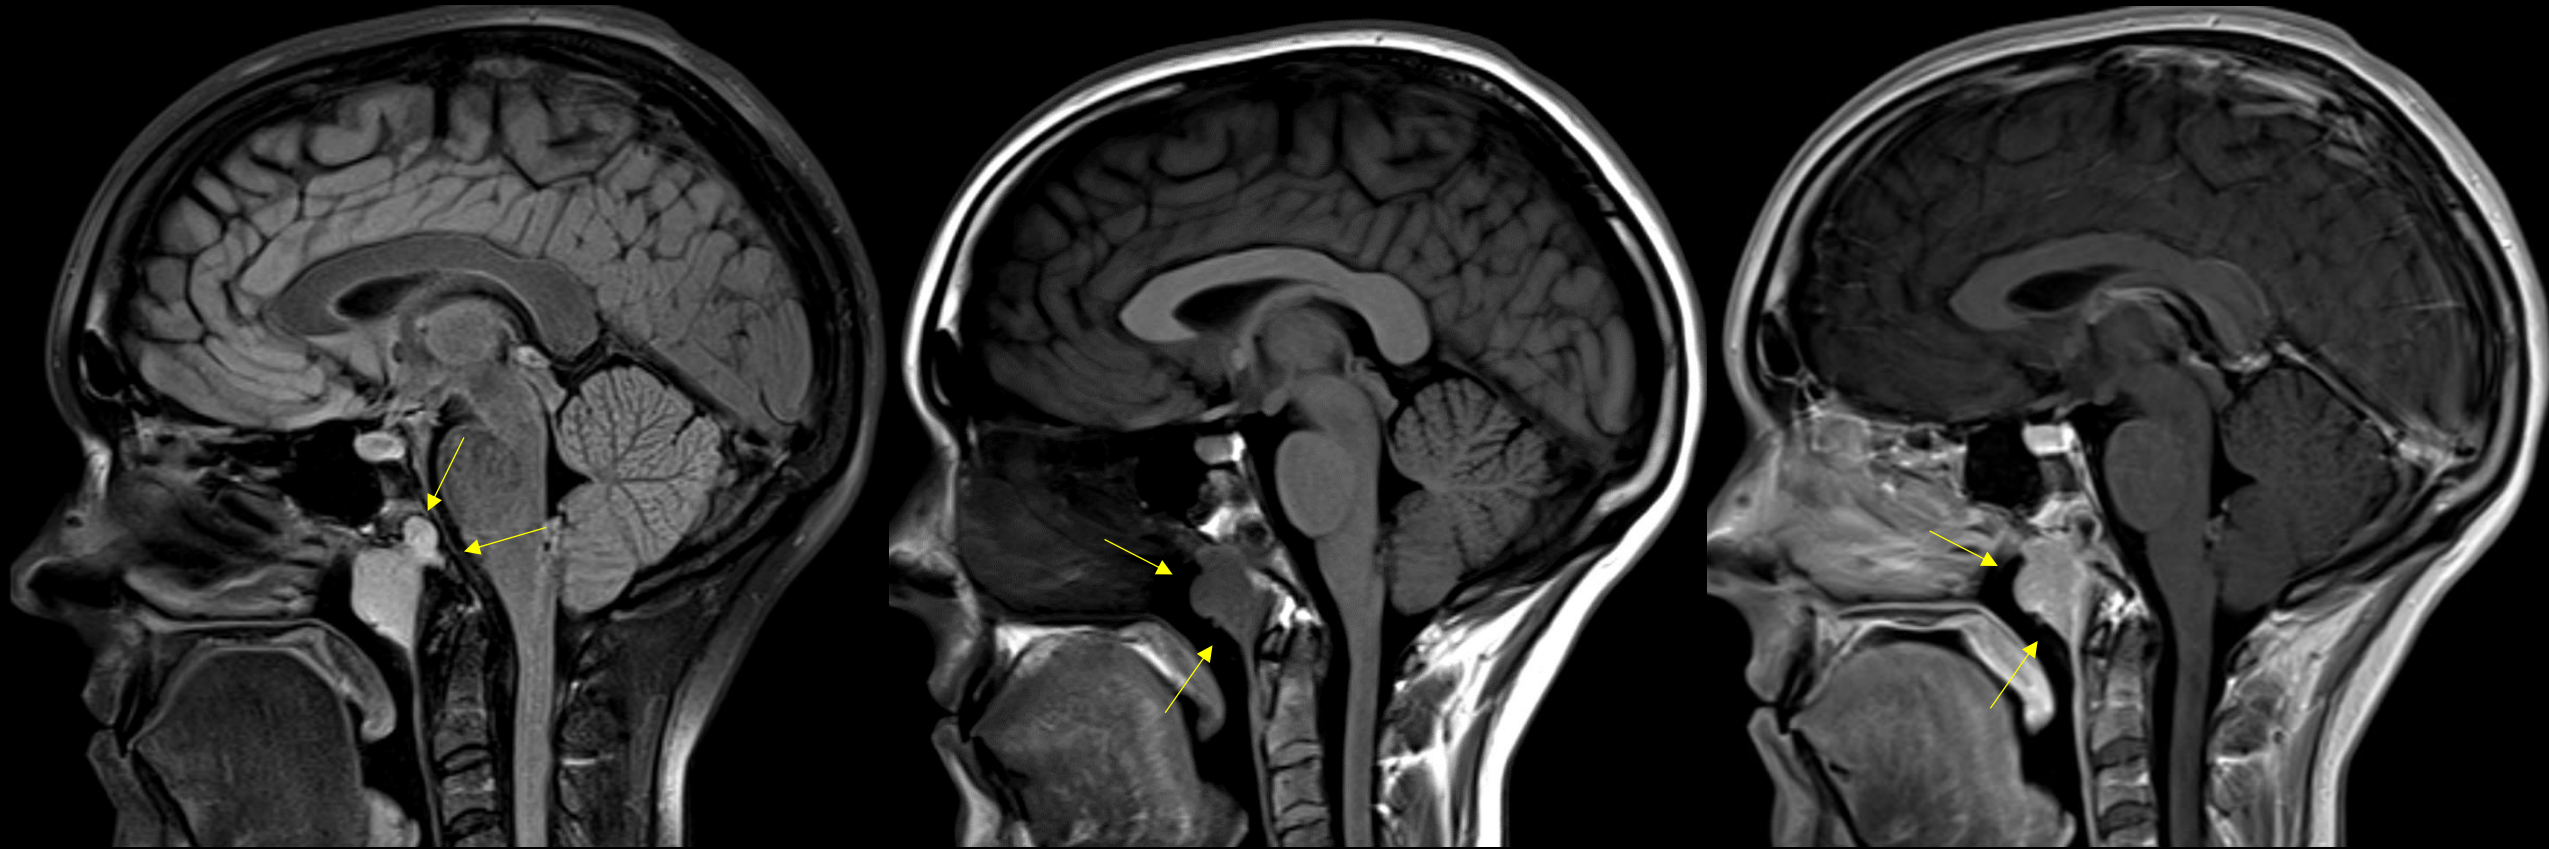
Sagittal FLAIR (A) image demonstrating clival defect (yellow arrows) involving the basiocciput, including the anterior margin, with relatively circumscribed margins and polypoidal soft tissue prominence in the nasopharynx. Sagittal T1W (B) and T1W CE (C) images showing enhancement of the nasopharyngeal soft tissue prominence (yellow arrows) with contiguous enhancement extending to the portion of the clival defect.
